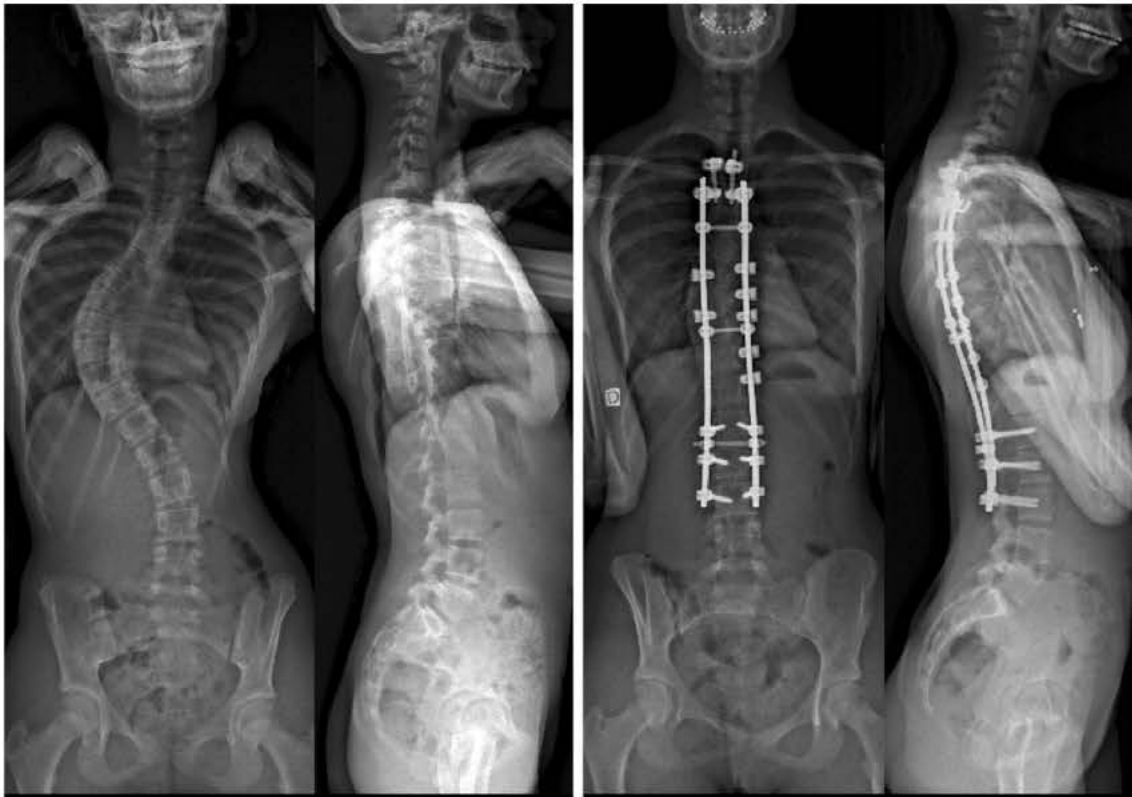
Preoperative and postoperative low dose radiographs of a Lenke 1 AIS patient treated by T3L3 posterior fusion using a hybrid construct with seven sublaminar bands
